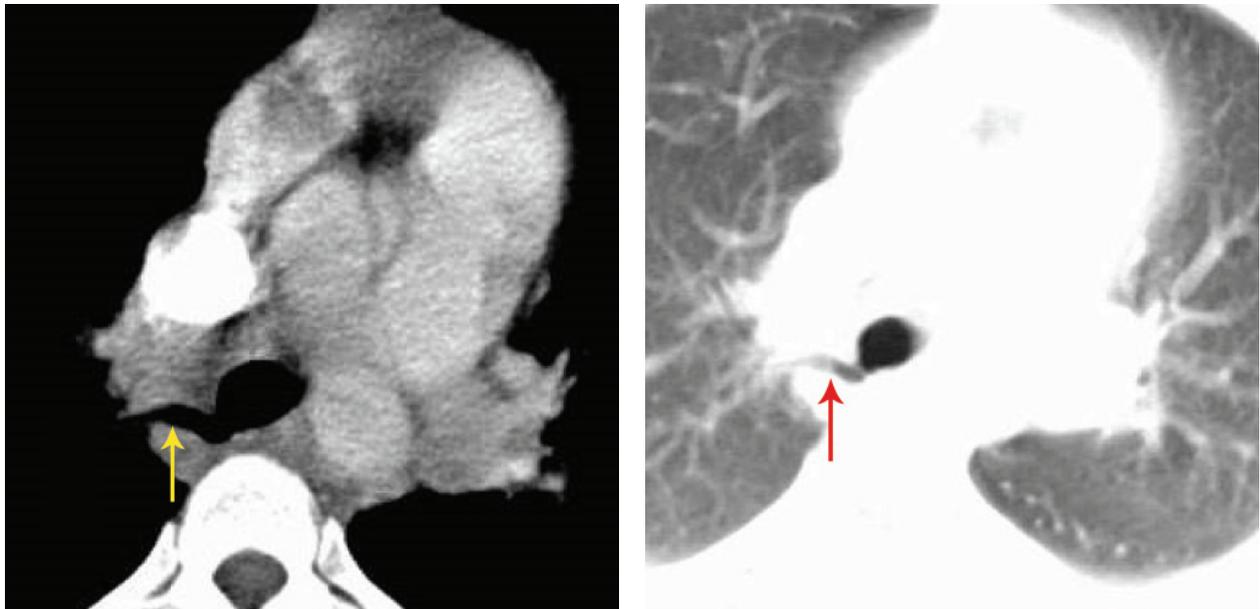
Images in mediastinal and lung windows of the computed tomography scan show an accessory bronchus arising from the right posterior wall of the trachea (arrow on figure 1). Also noted are enlarged lymphnodes
